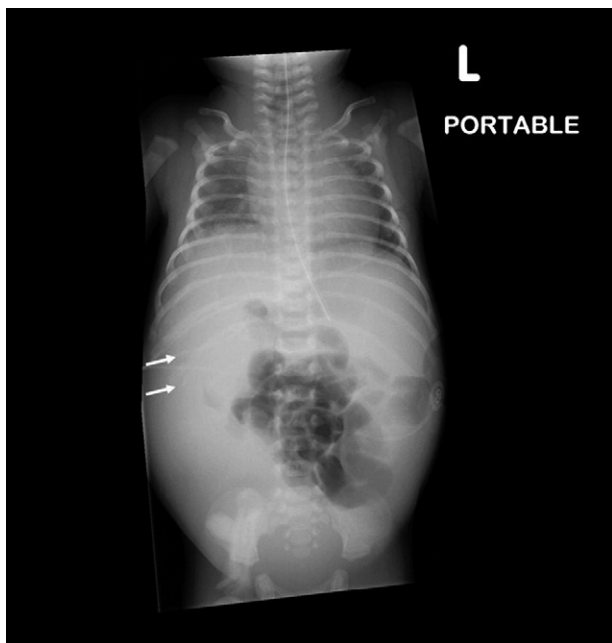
Chest and abdominal radiograph obtained at 12 hours of age. There is a lack of distal bowel gas, a few potential specks of peritoneal calcification (arrows), and the suggestion of a lower abdominal soft tissue mass.
